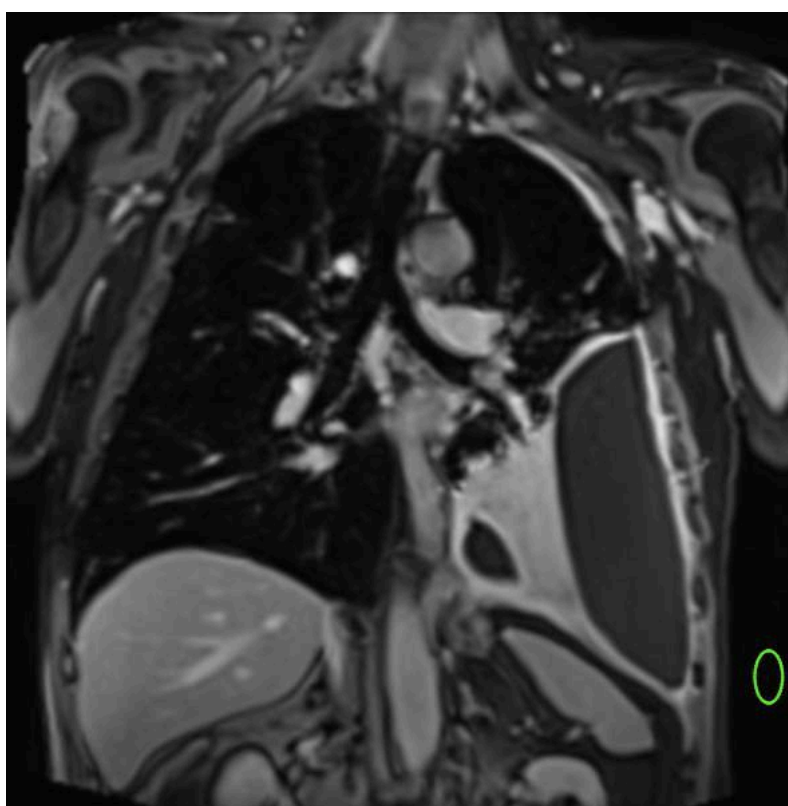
Contrast-enhanced, T1-weighted coronal MR image with a ROI placed on extra-corporeal air, used to correct for background signal noise
